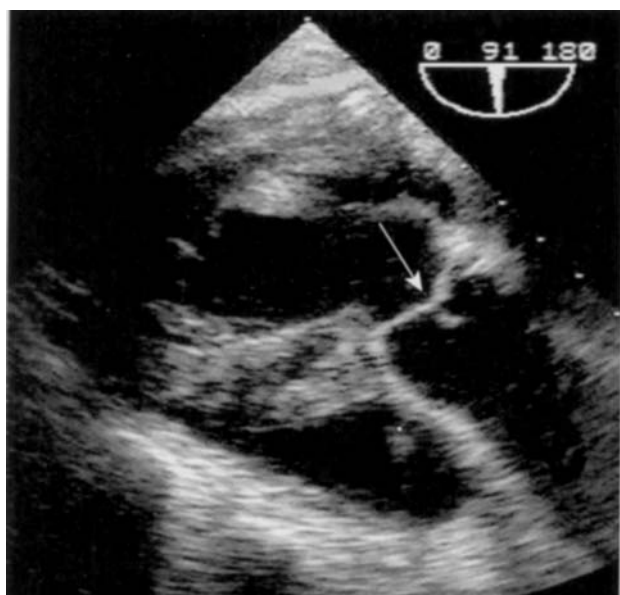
Transgastric long-axis view of the aortic valve; multiplane angle 91° . The arrow indicates the point of coaptation of the aortic valve cusps. This view is developed from the transgastric mid-papillary short-axis view by increasing the multiplane angle from 0° and is most useful for making spectral Doppler measurements of aortic valve flow.
